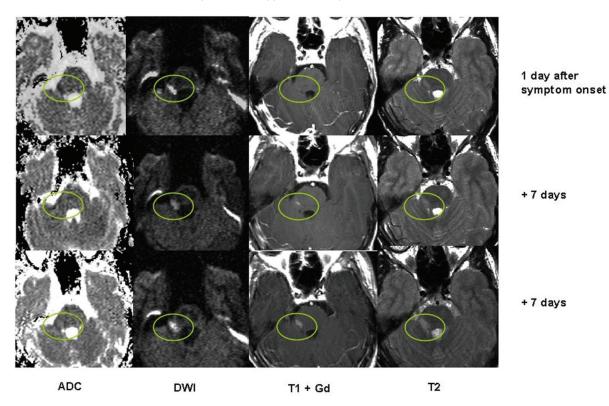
Exemplary ADC, DWI, contrast-enhanced T1-weighted, and T2-weighted images of the first 3 examinations of patient 9 in the first 15 days after new onset trigeminal sensory loss. The fascicular trigeminal fibers are affected by an acute lesion (circled in green). The lesion shows hyperintensity on DWI and a reduced ADC, while minimal T2 hyperintensity is noted without contrast enhancement on T1-weighted MRI initially. With time, the ADC pseudonormalizes and increases, while T2 hyperintensity and contrast enhancement become more prominent.
